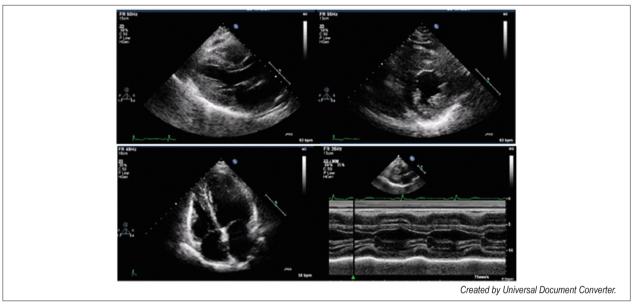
Second transthoracic echocardiogram.
